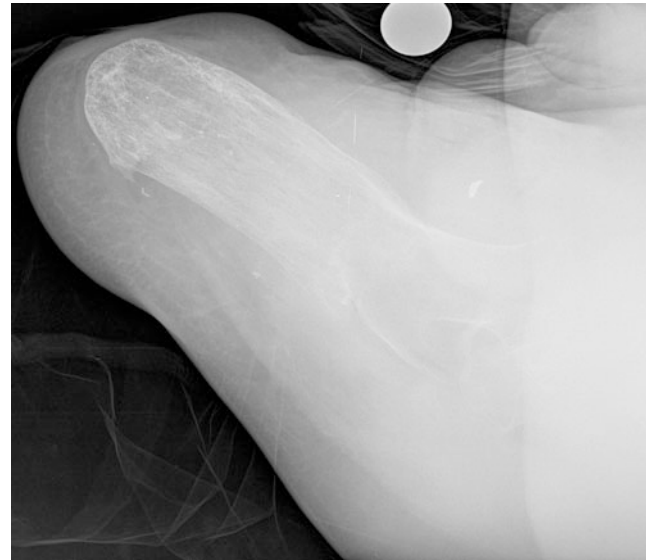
Lateral X-ray after complete consolidation
